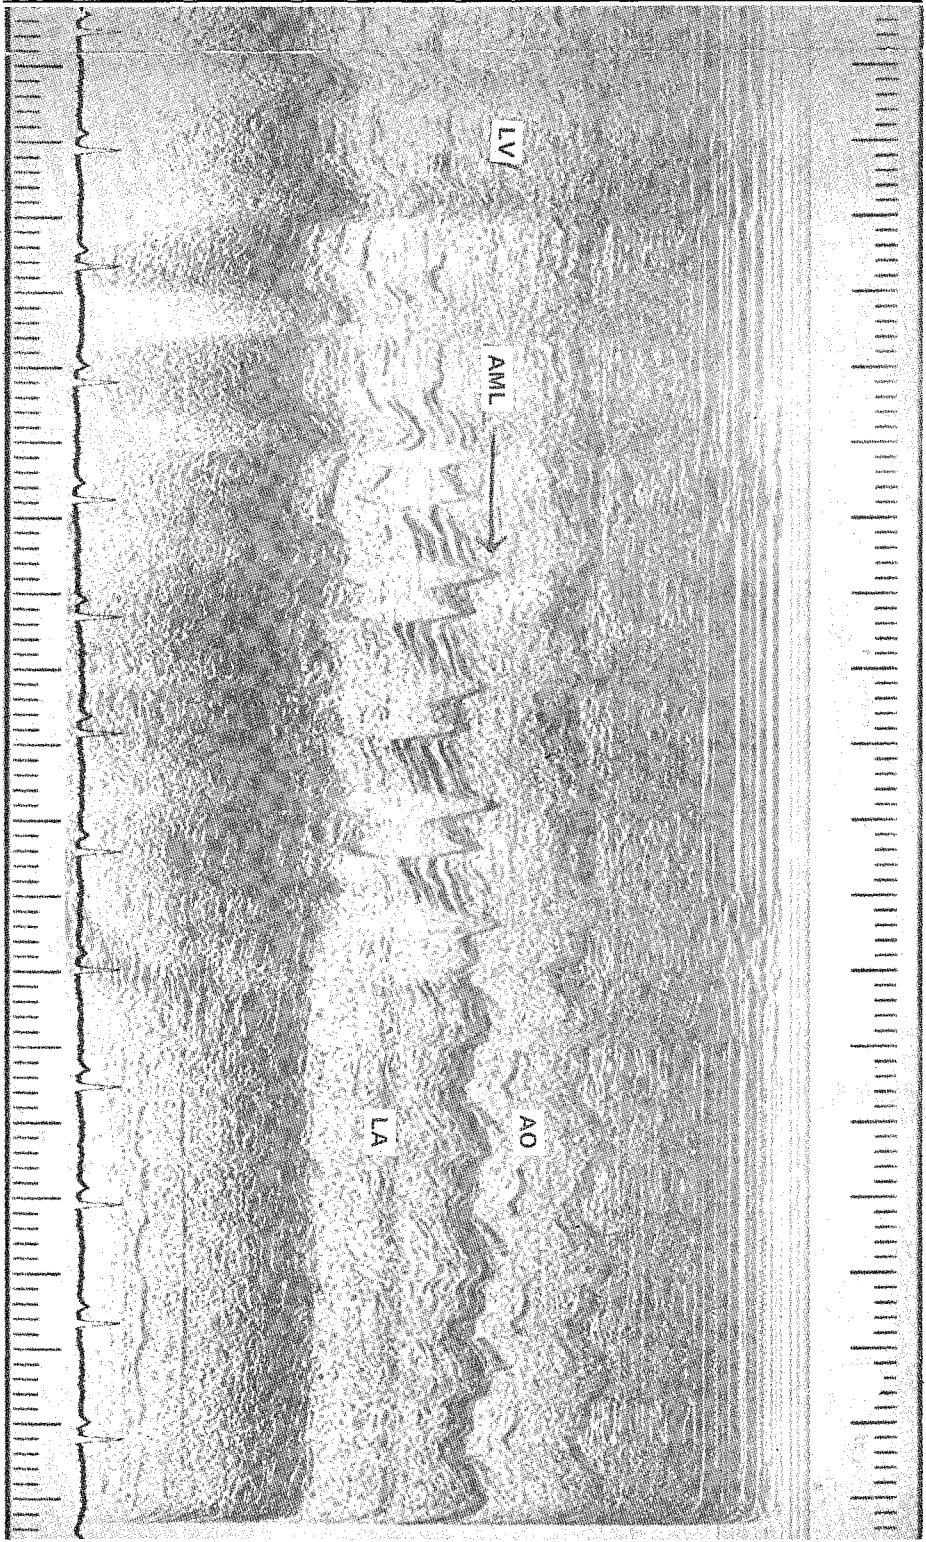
M-Mode Echocardiogram of the same patient after surgery. (Note that it has reverted to normal.)
